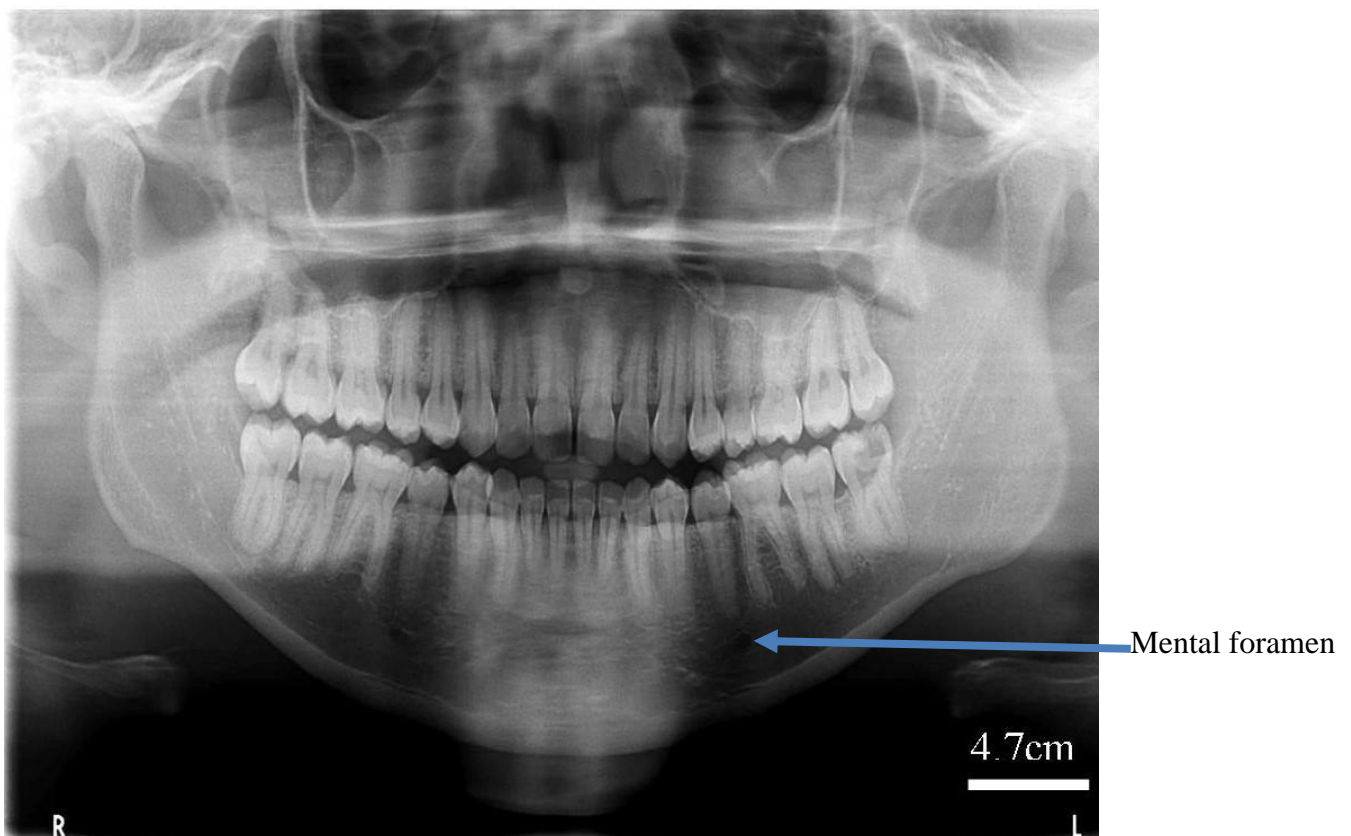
An orthopantomograph showing the mental foramen
